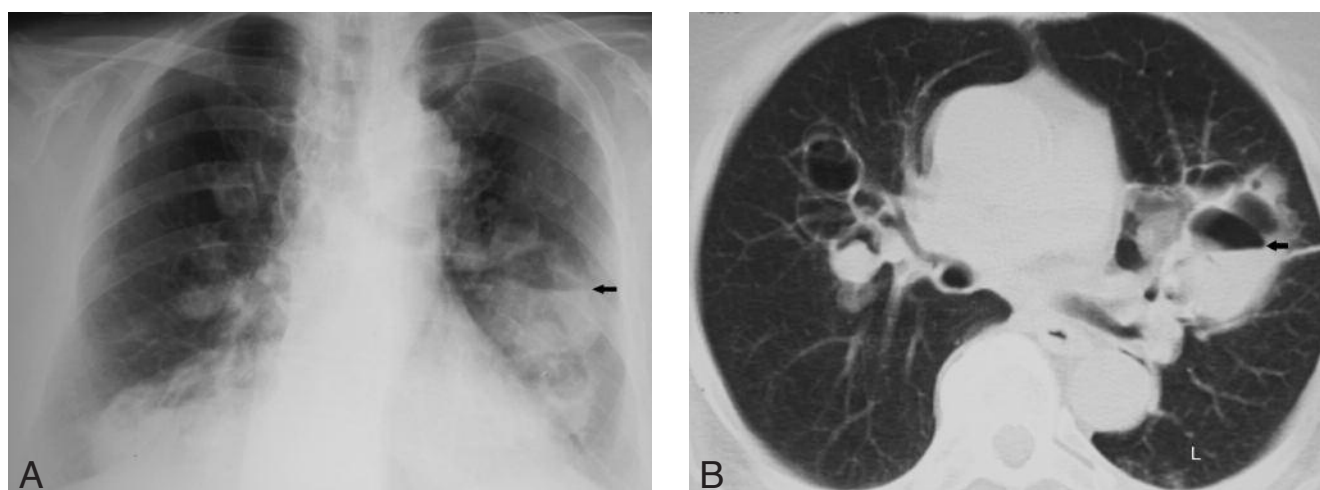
A. Posteroanterior chest radiograph two days after discharge on the second admission shows bilateral, multiple pulmonary masses with areas of cavitation. A large cavitary mass with air-fluid level (arrow) is seen in the left paracardial area. B. Chest CT scan (lung window) demonstrates bilateral, multiple solid and cystic lesions. Large cavitary mass on the left (L) contains air-fluid level (arrow). Note the variable thickness of the walls of the cavities.
